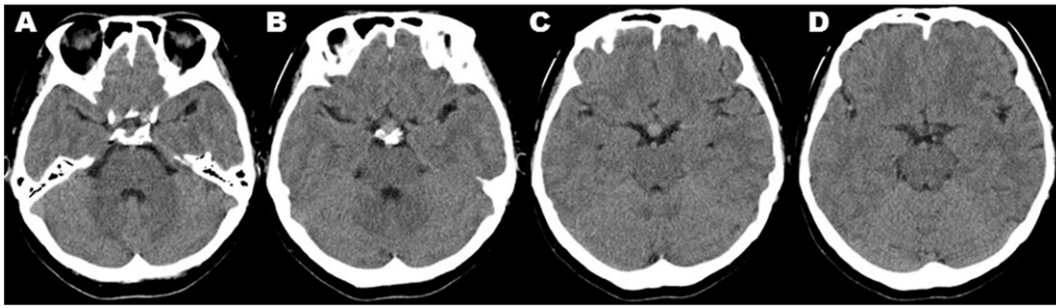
A small suprasellar (C), not intrasellar, tumor is shown on precontrast computed tomographic scan at the initial diagnosis. Since the tumor was asymptomatic, the patient wanted image follow-up of the lesion instead of surgery.
